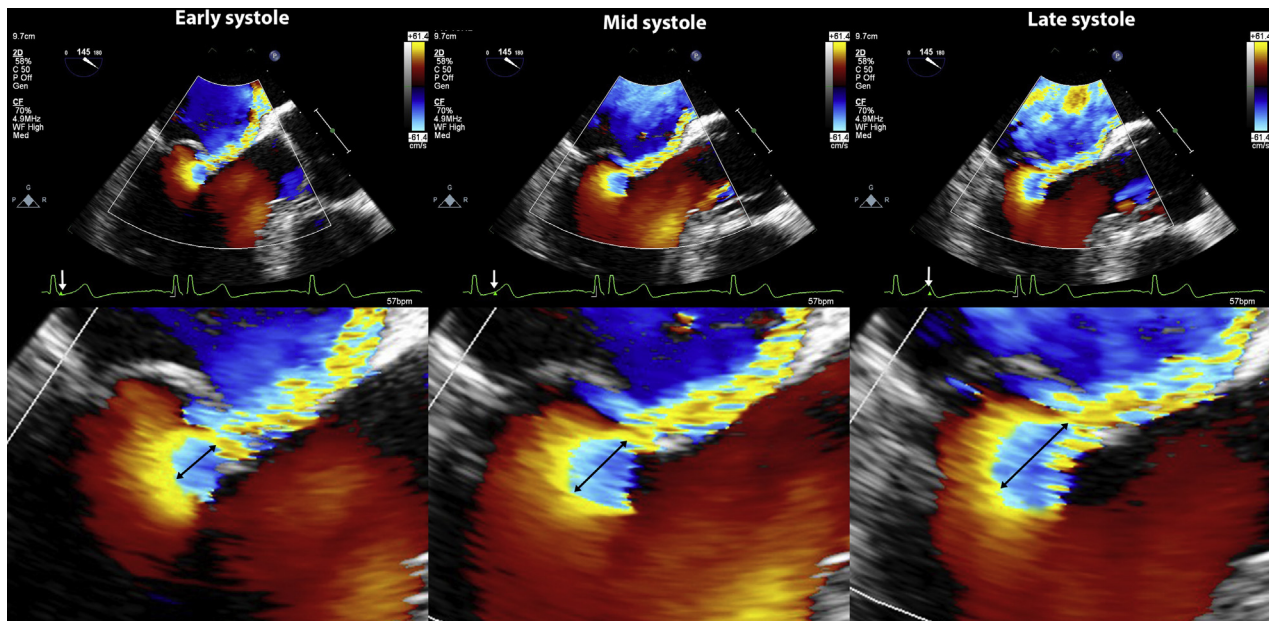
Increase in the radius of the PISA with color flow Doppler imaging from early to late systole in a patient with severe MR due to leaflet prolapse/flail. The increase in PISA radius (arrow) is reflective of increasing regurgitant orifice area. See text for details.
